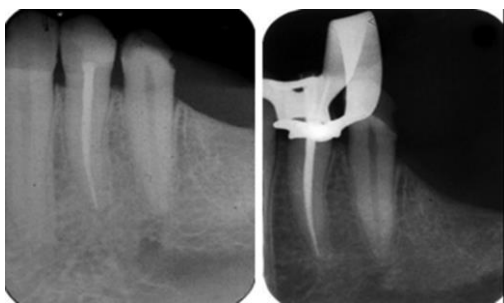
3 Comparison between (a) post-mortem (2009) and (b) ante-mortem (2008) periapical radiographs, revealing root canal treatment in the mandibular left first premolar and similar morphological structure adjacent to the mandibular left second premolar.
